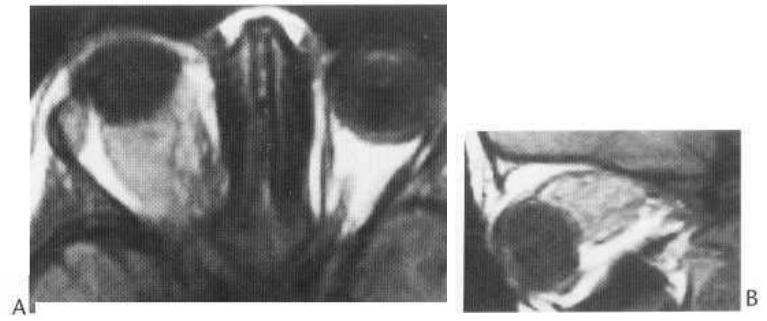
Cavernous haemangioma. T₁-weighted axial (A) and sagittal (B) MR images demonstrate proptosis of right globe due to well-circumscribed, mid to high signal intensity intraconal mass.
